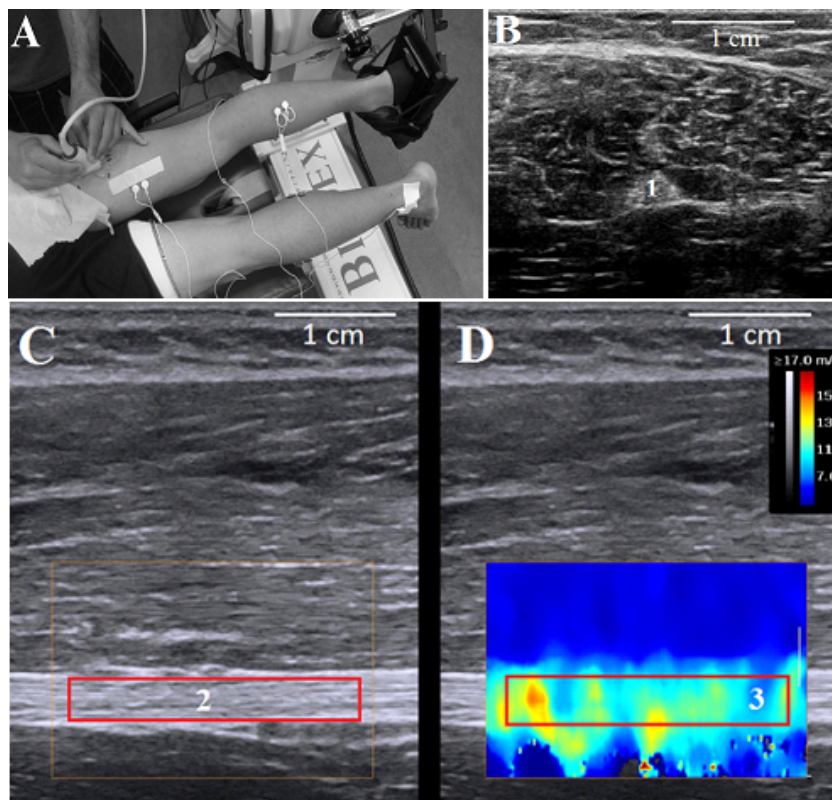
(A) Testing setup. B-mode sonograms of the sciatic nerve in (B) cross-sectional and (C) longitudinal views. The (D) elastogram window was defined over the nerve section, and the largest area within the epineurium was considered as region of interest
